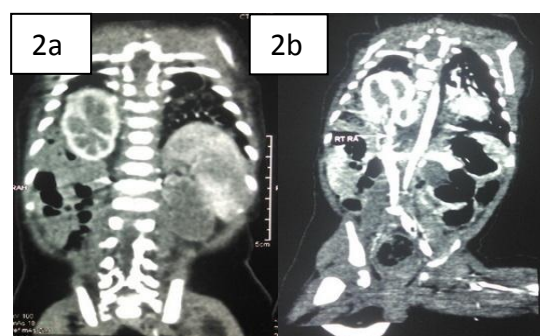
CT scan showing Herniation of small bowel loops along with right kidney in right posterior hemithorax through defect in posterior part of diaphragm (a). Right renal artery and vein appear stretched on CT angiogram (b)
